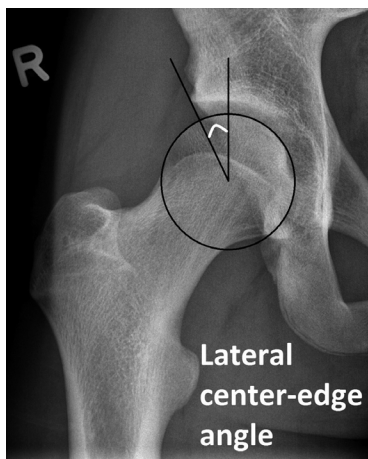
Lateral center-edge angle measurement on an anteroposterior X-ray of the hip joint (white angle)
